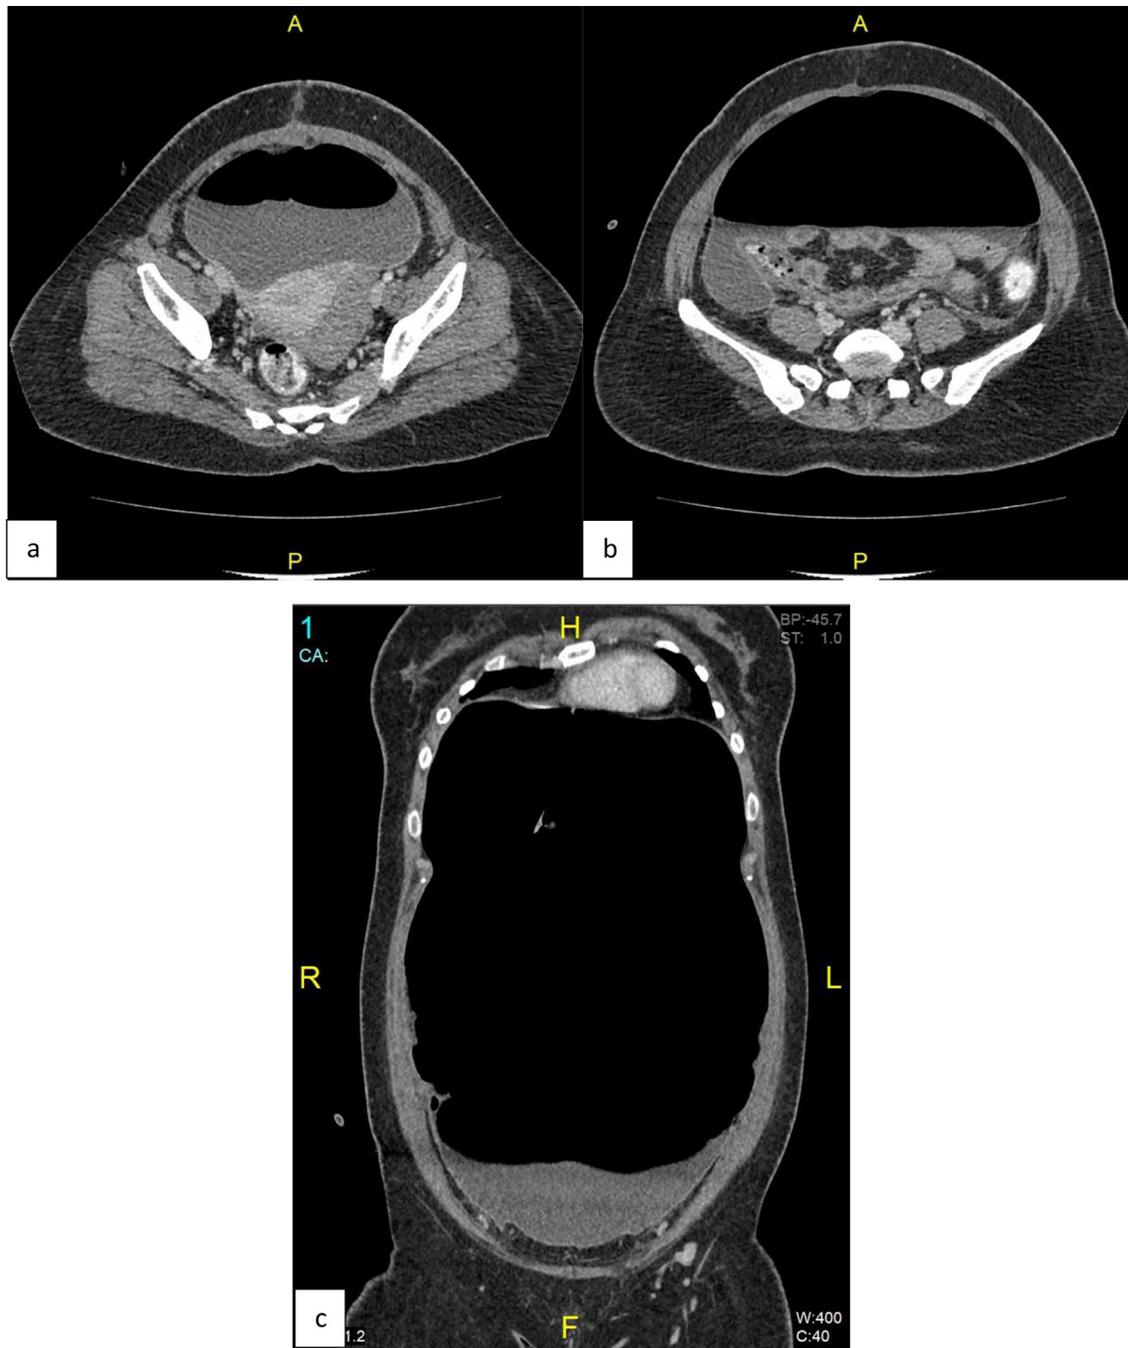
(A, B, and C): CT abdomen show a large well-defined, intra-abdominal collection with air-fluid level with peripheral peritoneal enhancement.
